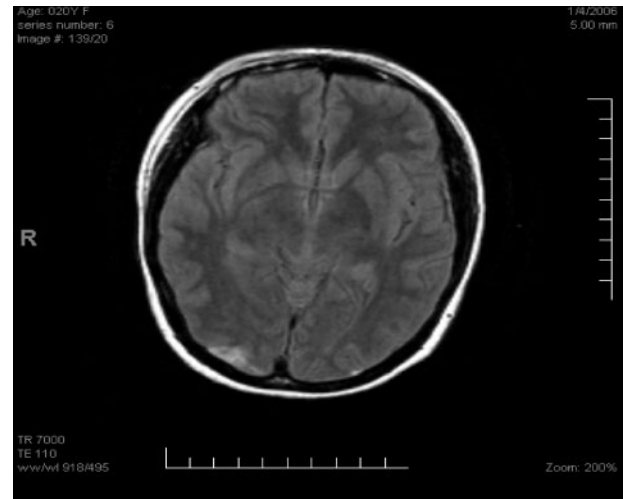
FLAIR MRI of the patient obtained on 4 January 2006, showing almost complete resolution of the bilateral occipital lesions.
